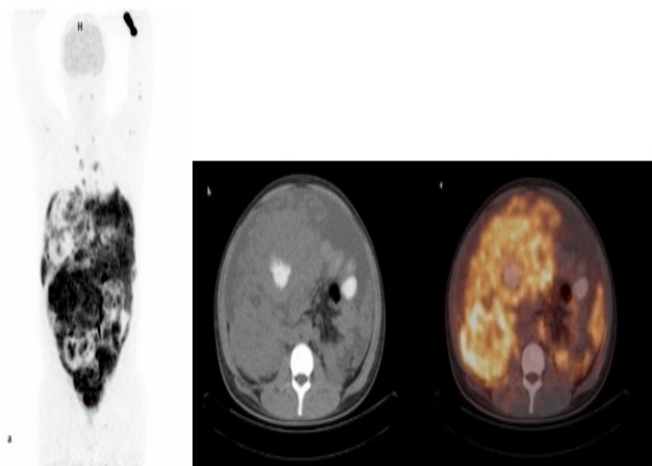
MIP (a), transaxial CT (b) and fusion (c) F-18 FDG PET/CT images of a 15 years-old male patient. Abdominal lymph node biopsy revealed high grade malign B cell lymphoma (Burkitt). On F-18 FDG PET/CT imaging, there were multiple hyper-metabolic mediastinal, abdominal, pelvic lymph nodes, massive abdominal fluid and bone marrow involvement
